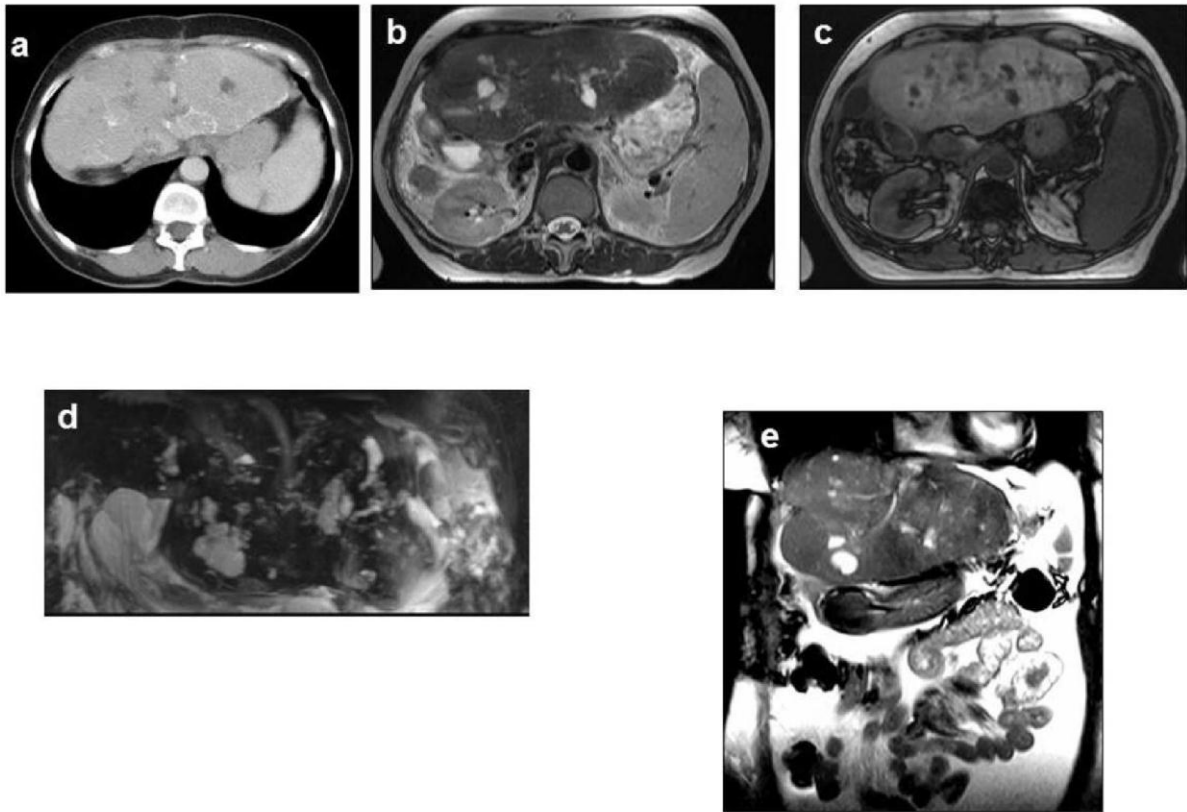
Post-chemoembolization cholangiopathy with secondary biliary cirrhosis and ascites. 60 years old female cholangiocarcinoma patient underwent TACE for liver remnant multiple recurrent tumors. CT (a), MRI T1-WI (b), T2-WI(c) and MRCP (d) shows multiple strictures and postnecrotic cysts of bile ducts, non-neoplastic nodularity of the liver with evidence of ascites at coronary T2-WI (e).
